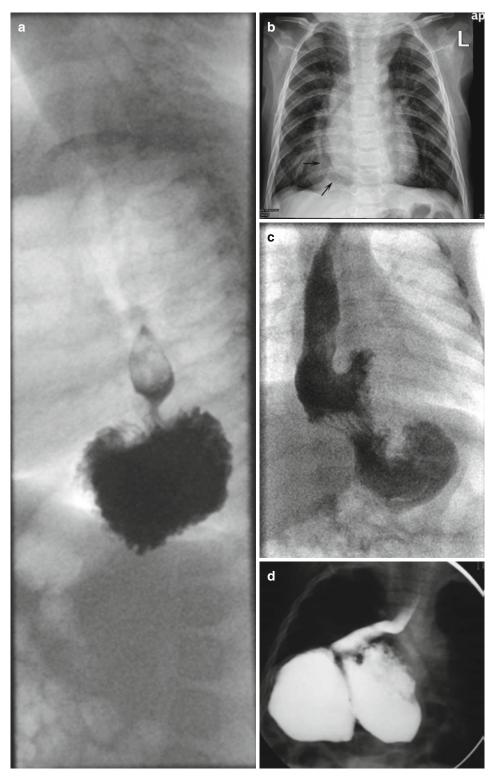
(a–d) Radiographic imaging of hiatal hernias. (a) Barium swallow demonstrating a type I hiatus hernia. (b) Frontal chest radiograph showing a retrocardiac lucency
